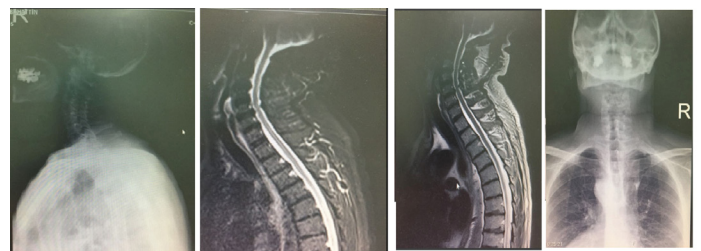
MRI image of hinging cervical involvement
